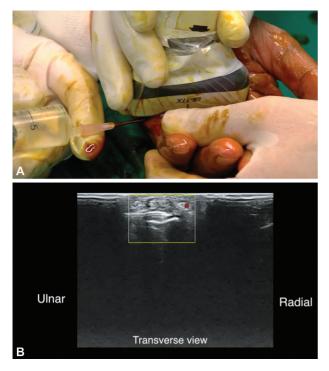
(A, B) Ultrasound-guided aponeurotomy in Dupuytren disease. Release of the proximal interphalangeal (PIP) joint. Doppler showing the location of the neurovascular bundle.
